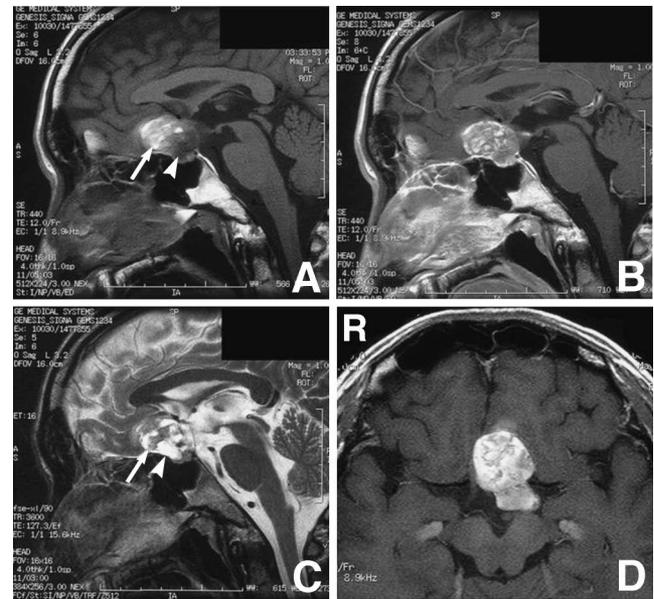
A–C: Sagittal T₁- (A) and T₂-weighted (C) magnetic resonance (MR) images revealing a lesion as heterogeneous intensity in the sellar turcica, with slight enhancement by gadolinium-diethylenetriaminepenta-acetic acid (Gd-DTPA) (B). T₂-weighted MR image revealing a hypointense area consistent with the hyperintense region (A, C: arrow) on T₁-weighted MR images, indicating the presence of an intratumoral hemorrhage, and a hyperintense area consistent with the hypointense region (A, C: arrowhead) on T₁-weighted images, suggesting the presence of a cartilaginous lesion. D: Axial T₁-weighted MR image with Gd-DTPA revealing the tumor extending to the left cerebral peduncle.
